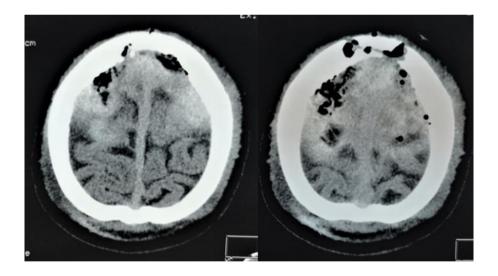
Postoperative axial CT tomograms show complete evacuation of the hematoma and minimal gas inclusions in the operating area.
